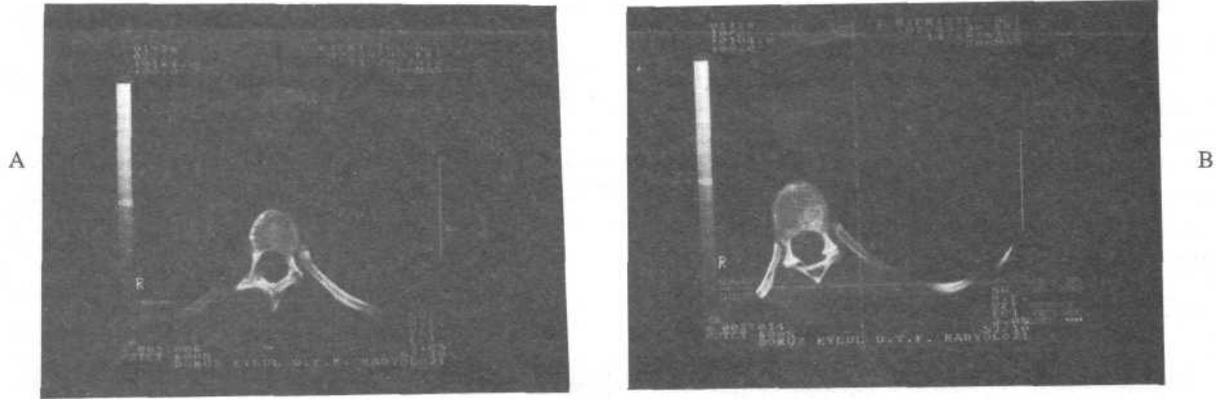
A: Single slice CT scan is obtained through the neutral vertebra.
